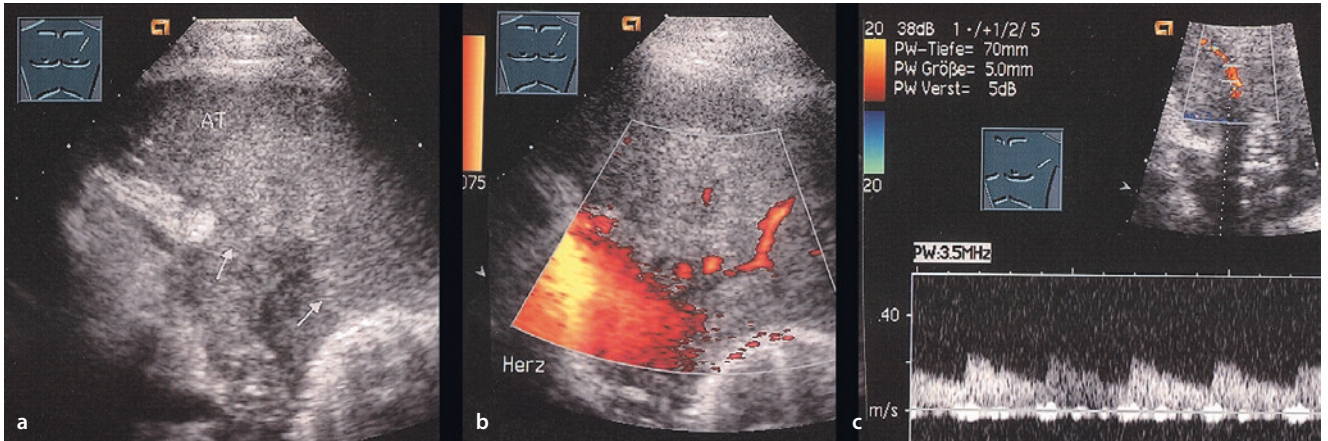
A 36-year-old man with Hodgkin's disease in the mediastinum. a On the B-mode image one finds a hypoechoic central tumor formation with atelectasis (AT; arrows). b Color-Doppler sonography shows limited vascularization within the atelectasis, which
